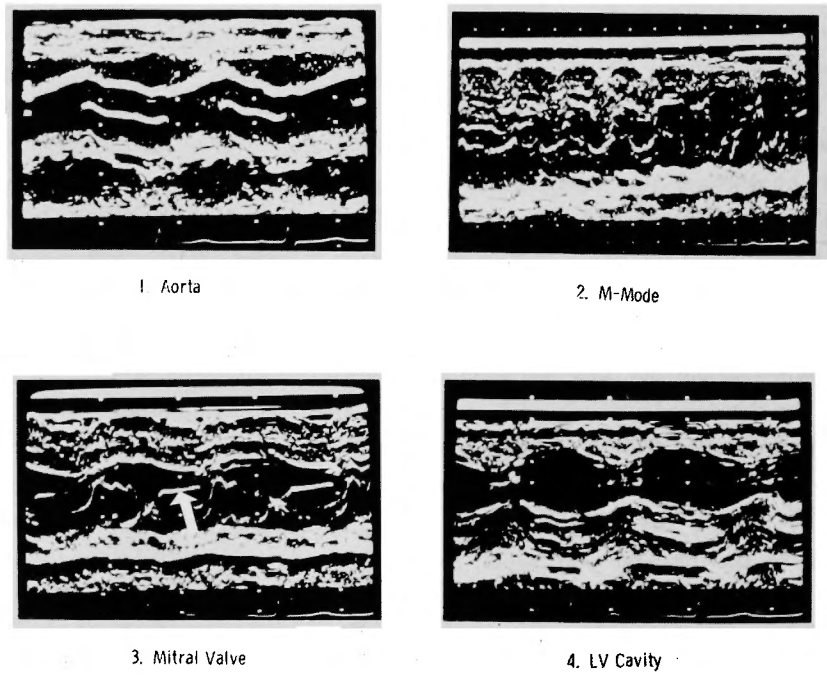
Echocardiography revealed left ventricular hypertrophy and systolic anterior motion of anterior leaflet of the mitral valve (arrow). The septal wall was much thicker than the posterior wall.
